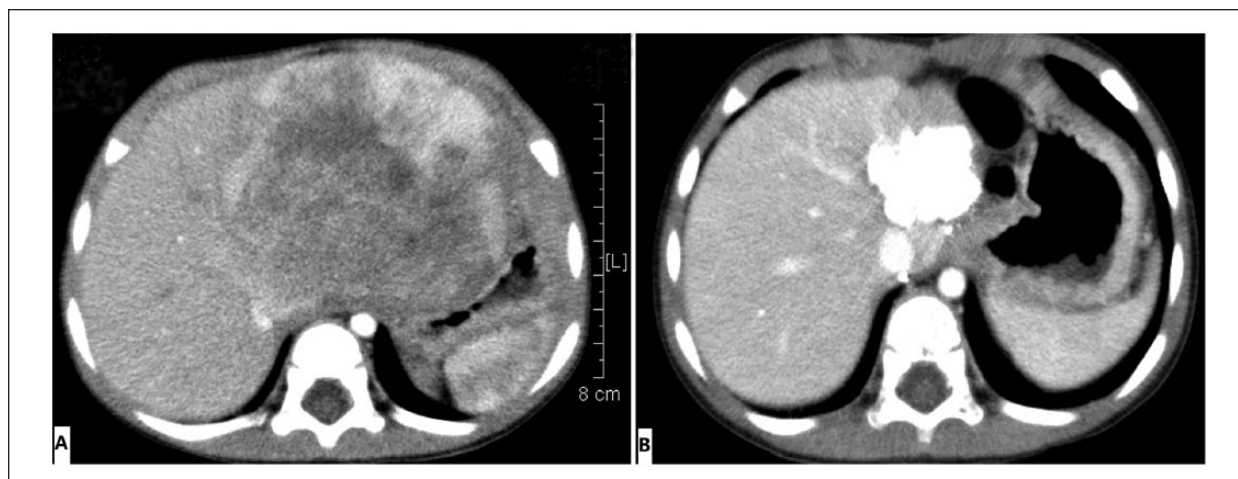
A. Computed tomography images before transcatheter arterial chemoembolization (TACE). B. Computed tomography images after the completion of TACE.
